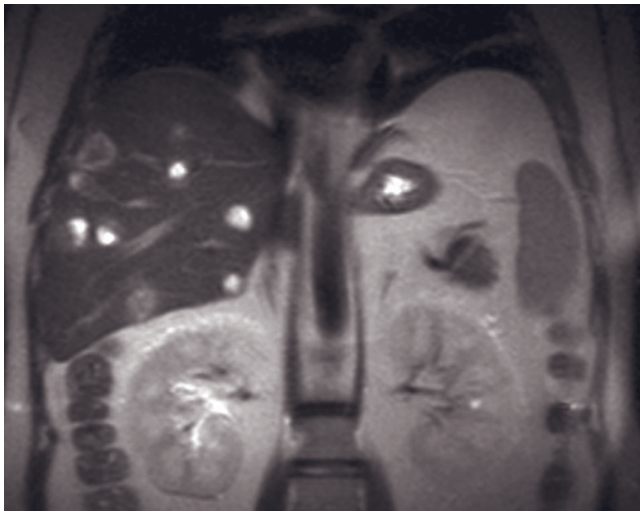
Hepatic abscesses. Coronal T2-weighted SS-ETSE (*a*), transverse SGE (*b*), and immediate (*c*, *d*), 45-s (*e*), and 90-s fat-suppressed (*f*) postgadolinium SGE images of the abdomen and sagittal T2-weighted SS-ETSE (*g*) and 2.5-min fat-suppressed postgadolinium SGE (*h*) images of the pelvis in a patient with appendicitis and hepatic abscess. There are multiple lesions with a cluster appearance in the right hepatic lobe that demonstrate high signal intensity on T2-weighted image (*a*), low signal intensity on T1-weighted image (*b*), and enhancement of the abscess wall and septations with perilesional enhancement immediately after administration of contrast (*c*). Abnormal enhancement of the liver on the early-phase image (*d*) reflects the presence of portal vein thrombosis, with increased enhancement of the right lobe due to increased hepatic arterial supply. The portal vein is expanded with thrombus (arrow *d*, *e*) that is low signal on T1-weighted image and does not enhance after administration of contrast, consistent with a bland thrombus. The portal vein wall enhances (small arrows, *f*) on the late-phase images, reflecting that the thrombus is infected. Note on the sagittal images (*g*, *h*) that the appendix (arrows, *g*, *h*) is thick walled with increased enhancement, consistent with acute appendicitis.
